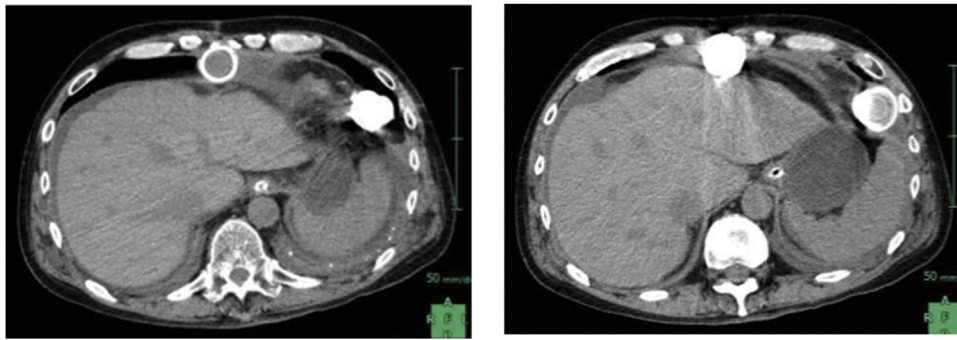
Abdominal CT scan at 2 months prior to the donor surgery. There was no obvious findings of liver cirrhosis, although liver appeared to be decreased in size compared to previous CT.
